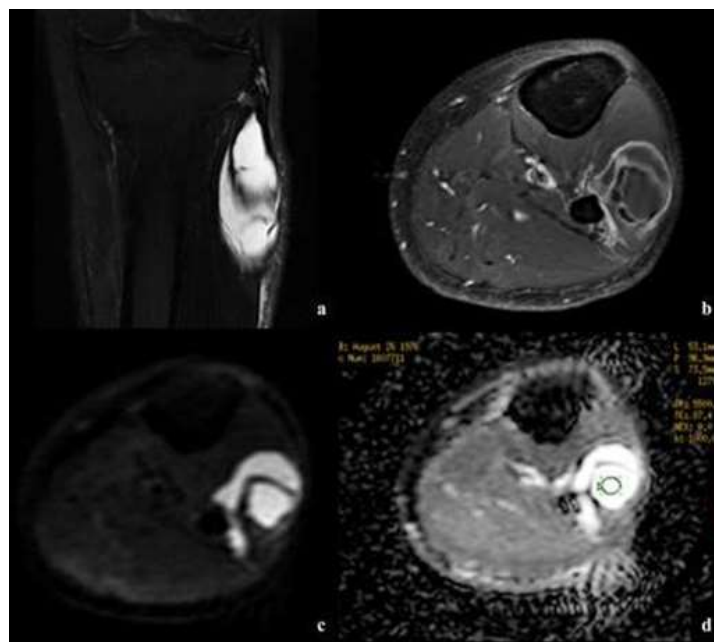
Coronal and axial MR images of a cystic soft tissue lesion at the level of the proximal leg. The lesion shows homogeneous internal fluid signal intensity with peripheral contrast enhancement, features suggestive for a perineural ganglion cyst of the common peroneal nerve. DWI sequences show values of 2.75×10^{-3} mm²/s (b value = 1000) on ADC map, confirming the benign cystic nature of the lesion.
